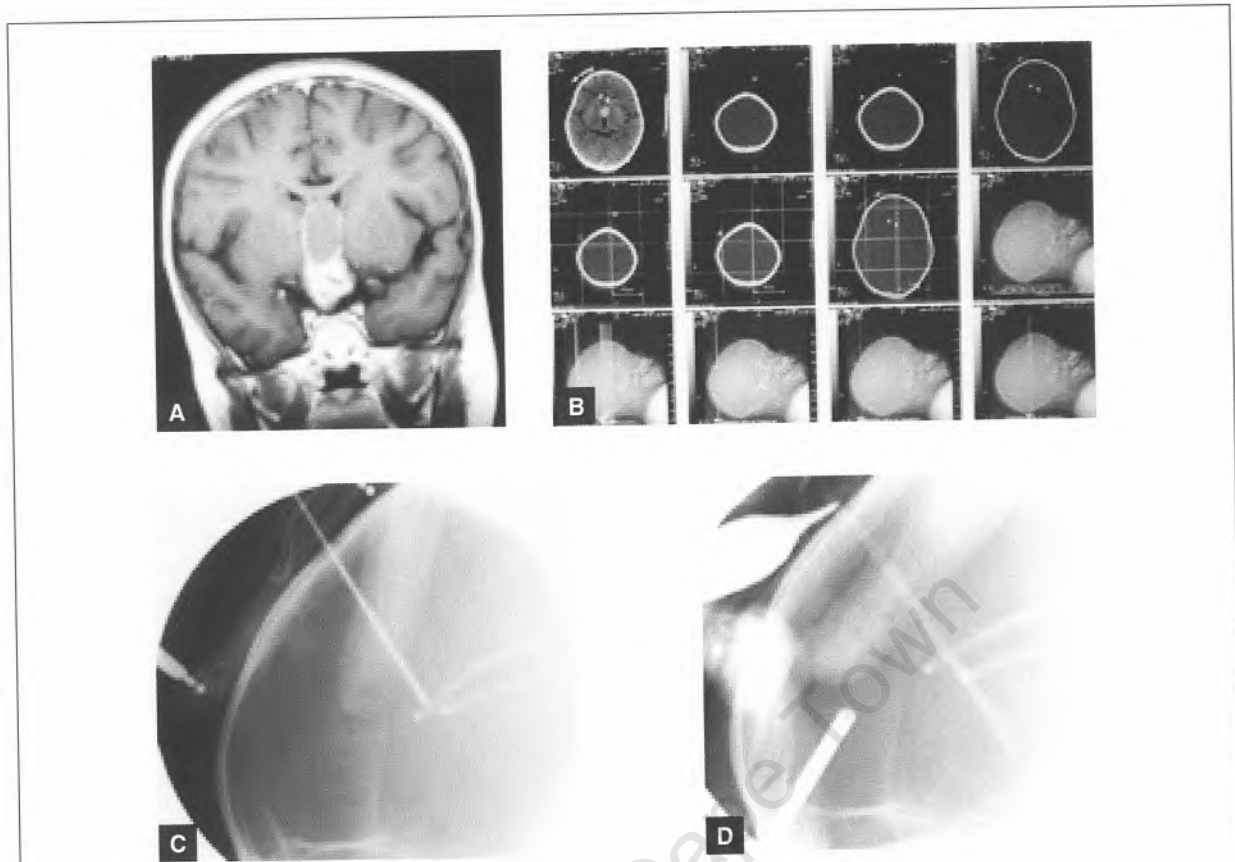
Corona MRI showing the typical appearance of a mixed solid-cystic craniopharyngioma (a) and the stereotactic planning scan (b). Upon inserting the catheter stereotactically with additional fluoroscopic control, it was clear that the trajectory was incorrect. As can be seen in (c), the catheter displaced the tip of one of the shunts; the halo and two of the feet of the tripod can just be identified in this image. Upon reinserting the catheter, the trajectory appeared to be directed anterior to the sella and therefore anterior to the suprasellar cyst (d).
